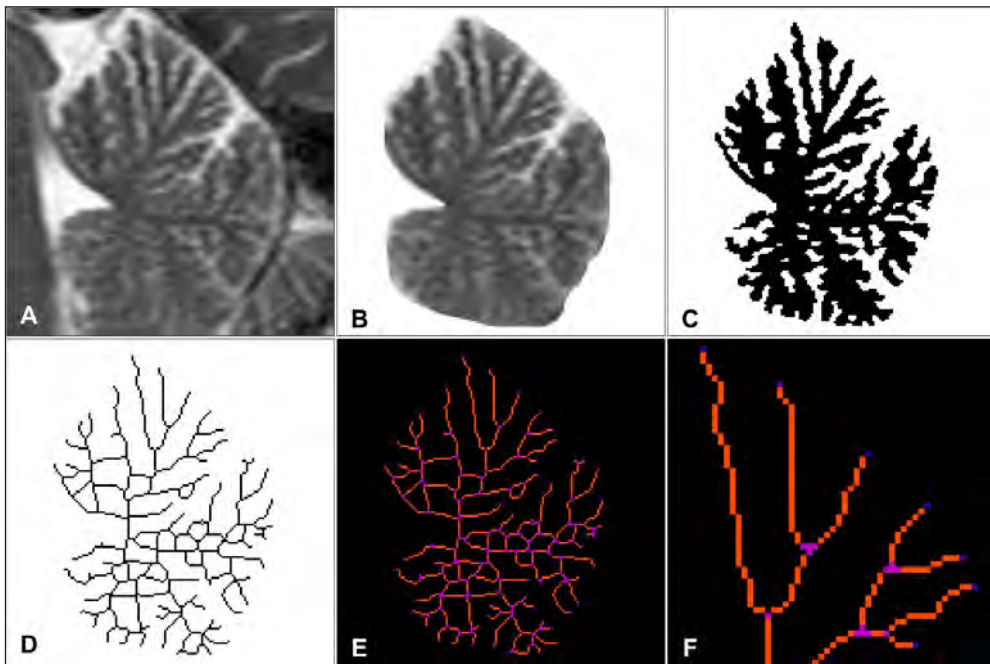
Cerebellar MR image analysis algorithm (T2-weighted image, midsagittal section of the cerebellar vermis). A – initial image; B – background removal; C – segmentation of the overall cerebellar tissue; D – skeletonization; E, F – quantitative analysis of digital skeleton: slab pixels (forming branches) are shown in orange, junction pixels in purple, and end-point pixels in blue
